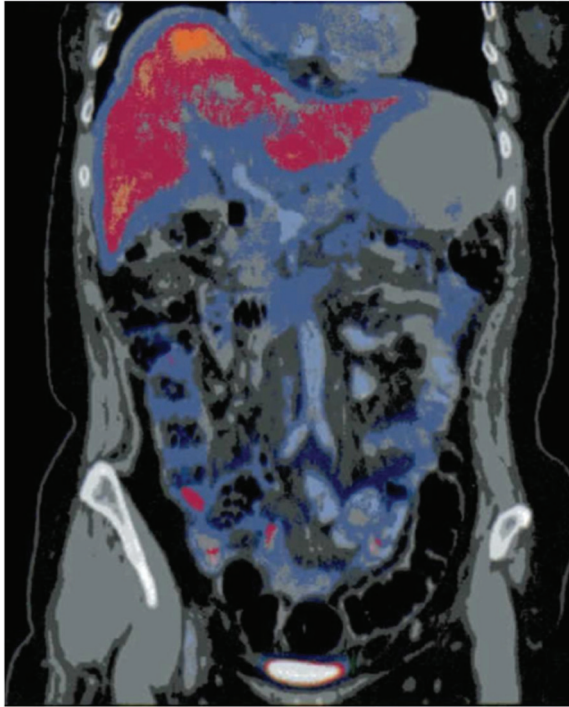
PET/CT reported metabolic increase in the cecum and ascending colon.
